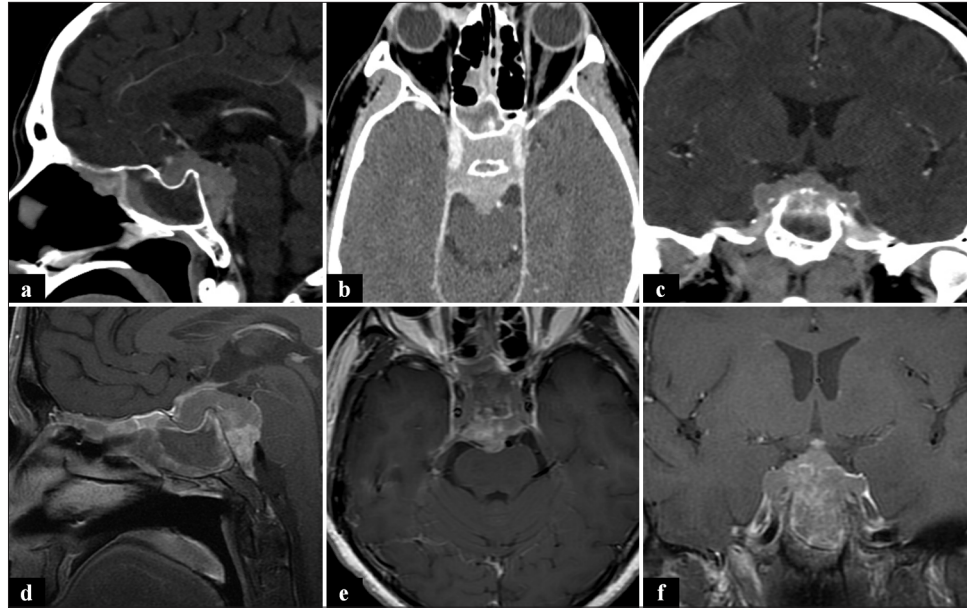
(a-c) Head computed tomography with contrast demonstrating an enhancing mass in the sellar/suprasellar region and additional multifocal areas of mucosal thickening and enhancement along the walls of the sphenoid sinus. (d-f) T1-weighted contrast-enhanced magnetic resonance imaging demonstrating a contrast-enhancing mass centered on the sella and cavernous sinuses.
